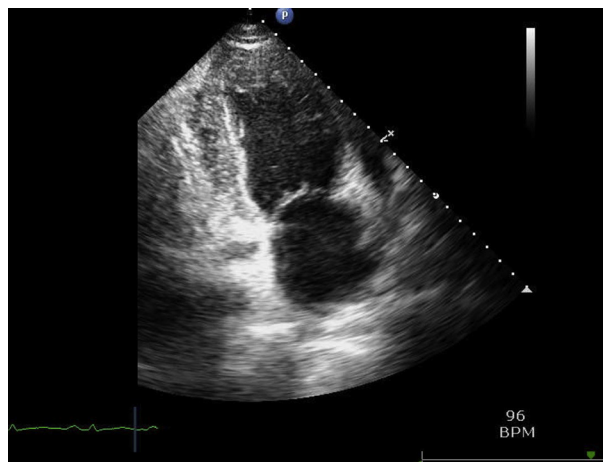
Apical two-chamber view revealing a mildly dilated left ventricle and normal left atrial size.
